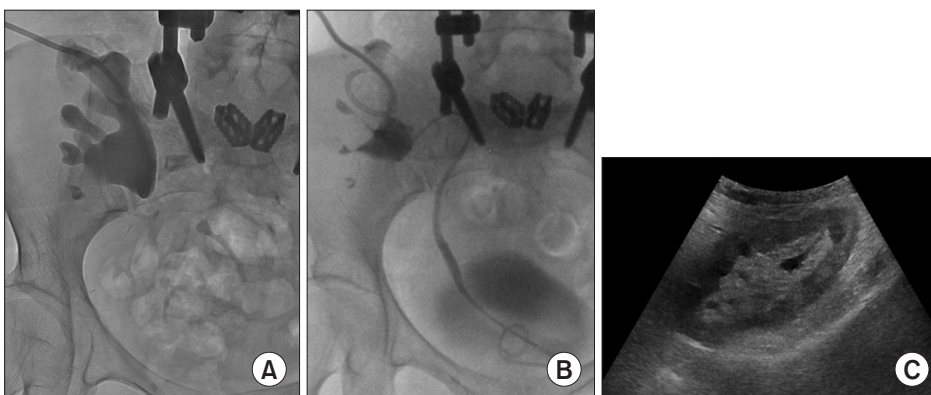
Case 1. Antegrade pyelography images before surgery (A) and 2 weeks after surgery (B). (C) Sonography of the transplant kidney at 4-month follow-up showed no sign of hydronephrosis.
